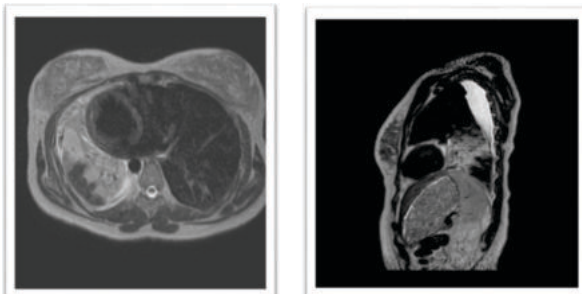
MRI image of the left lower lobe consolidation with pleural effusion (T2WI Axial and Sagittal views)
